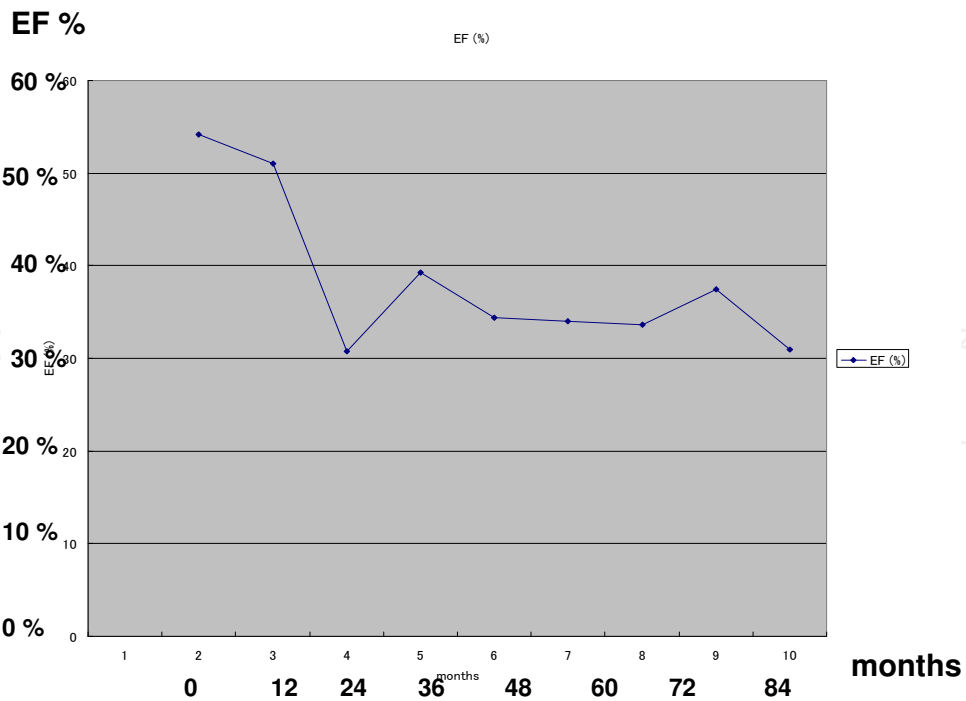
Longitudinal course of the ejection fraction on UCG 74-year-old female, nonsmoker, eye, renal stone, BHL, ACE 28.3, heart with complete AV block Ordinate: ejection fraction (%) on echocardiography Abscissa: months from the introduction of therapy
